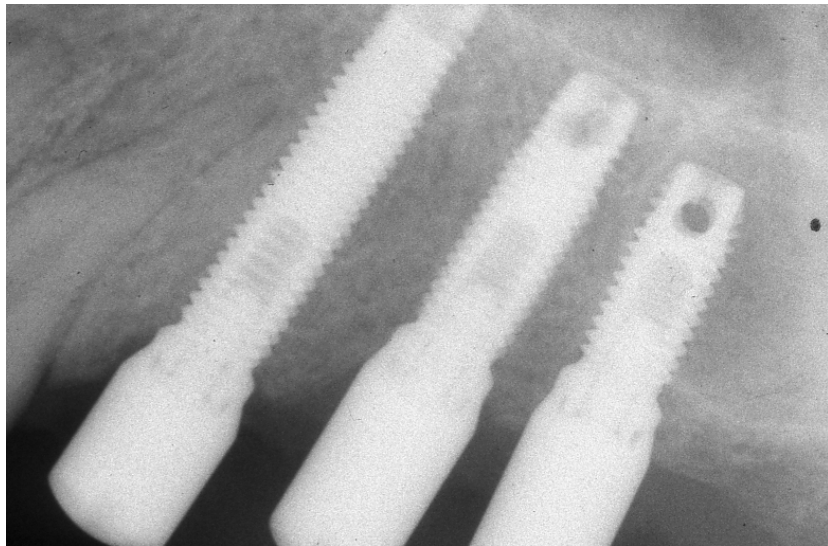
Periapical radiograph taken at the time of the second stage implant treatment
